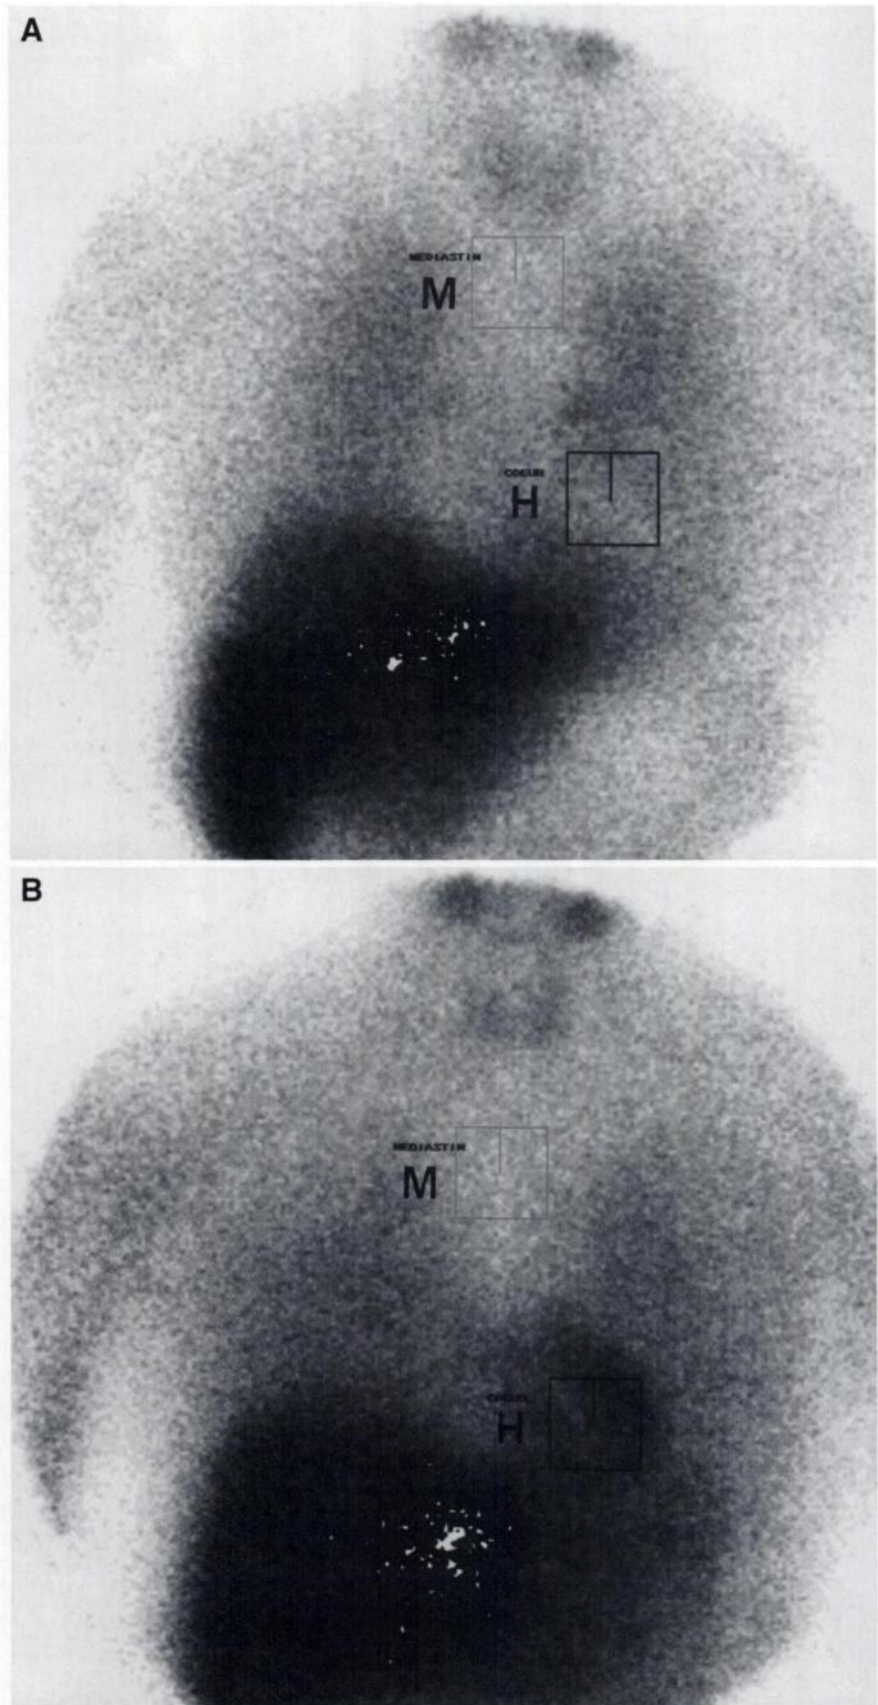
(A) Planar scintigraphic image of anterior view of chest of 54-y-old man 4 h after ^{123}I -MIBG intravenous injection and before carvedilol (t0). Heart (H) and mediastinum (M) were selected as shown to measure heart-to-mediastinum ratio activity (HMR). HMR was evaluated as 111%. (B) Planar scintigraphic image of anterior view of chest 4 h after ^{123}I -MIBG intravenous injection after carvedilol (t6). Significant increase in cardiac MIBG uptake was observed (HMR = 162%).
